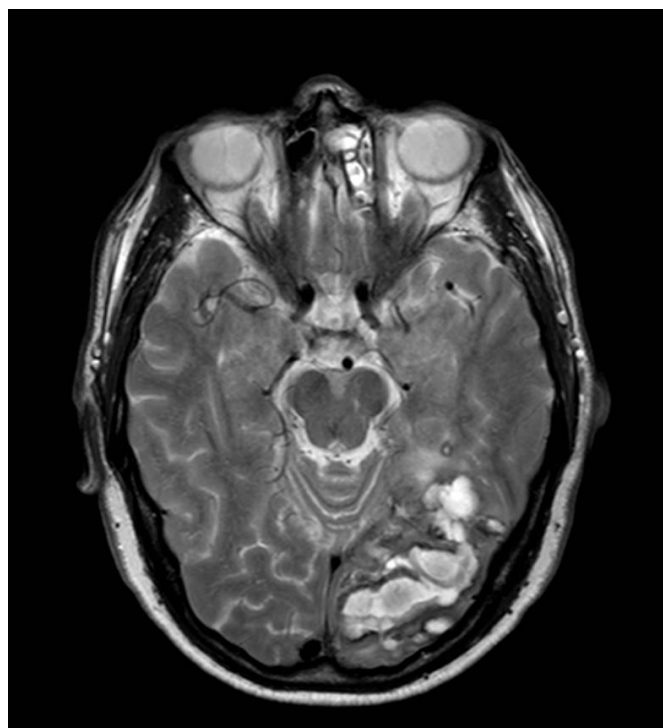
Axial T2 weighted MRI scan showing haemorrhage in the left occipital lobe. Superficial siderosis and distant microhaemorrhages were not seen on T2*-weighted sequences performed post-operatively.
